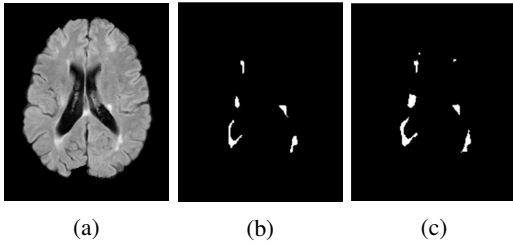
Examples of FLAIR image (a) with the corresponding masks annotated by Rater 1 (b) and Rater 2 (c), respectively. To note that, different Raters have different decision about pixel location in the mask.
